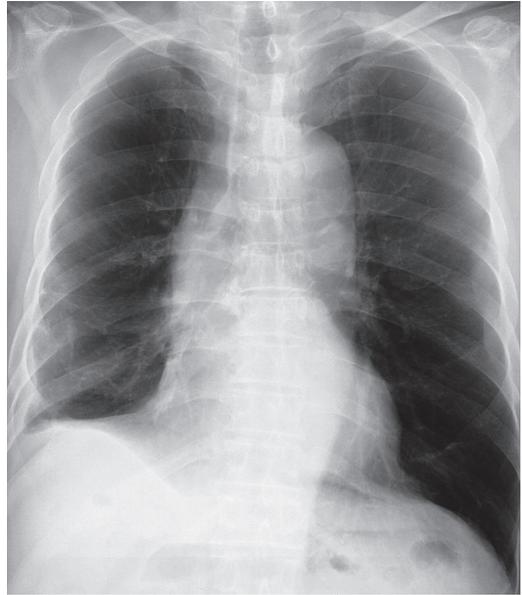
Chest radiograph, 2 years after discontinuance of dantrolene, the right-sided costophrenic angle persisted blunt as the scar of inflammation.
